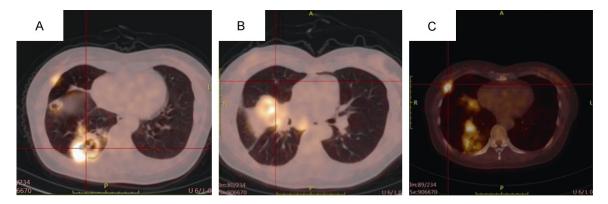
PET-CT scan of the thorax showing high 18F-FDG value in the upper lobe nodule (B) and lower lobe cavity (A), and a solitary nodular implant in the right rib (C).
